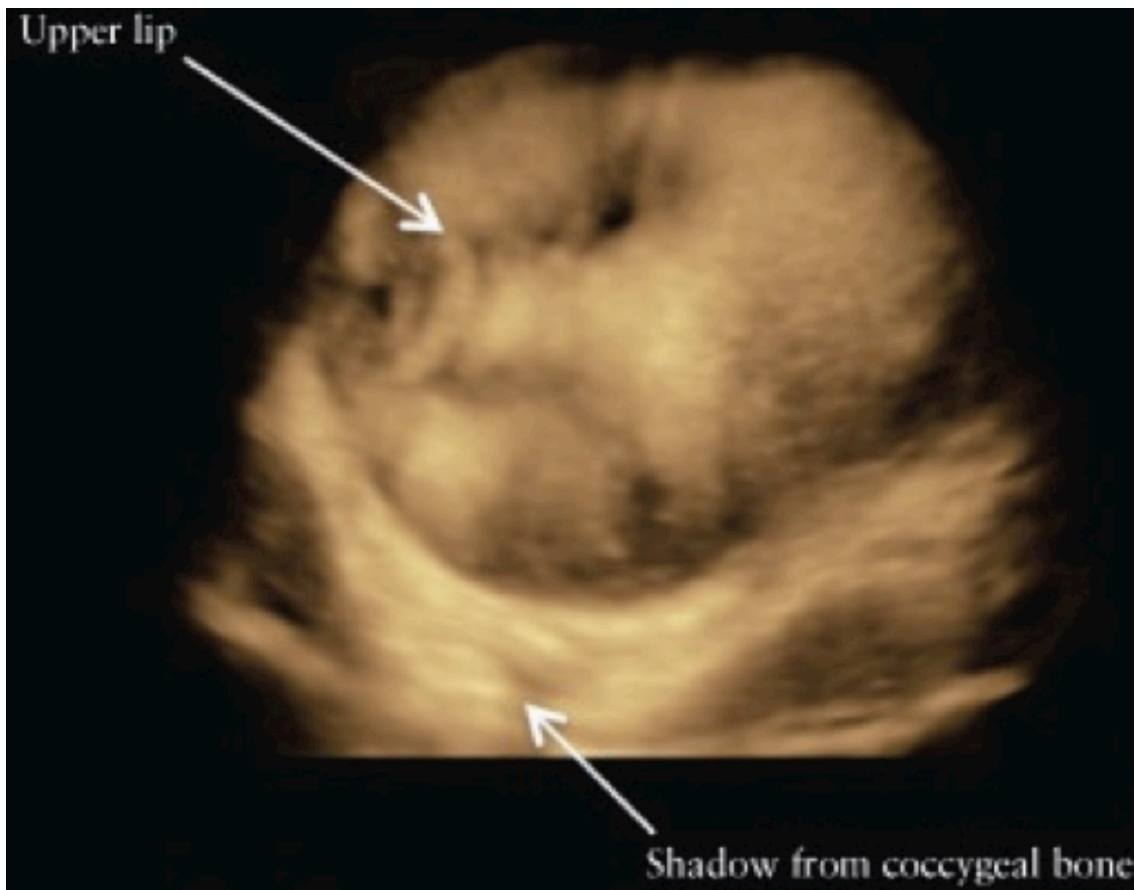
Face presentation diagnosed on 3D ultrasound. Printed with permission.³⁹
